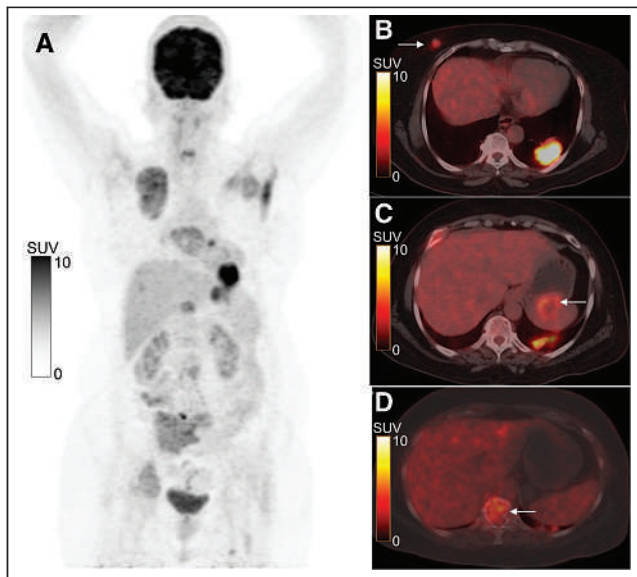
Maximum-intensity-projection PET image (A) and transaxial PET/CT images (B, C, and D) showing ^{18}F -FDG-avid lesions in right breast (B, arrow; SUV_{max} , 3.6), spleen (C, arrow), and D12 vertebra (D, arrow) (nonavid on whole-body iodine scan).
